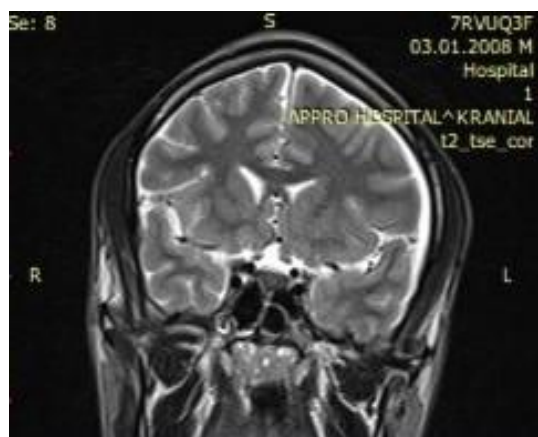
Coronal section cerebral MRI, coronal section
